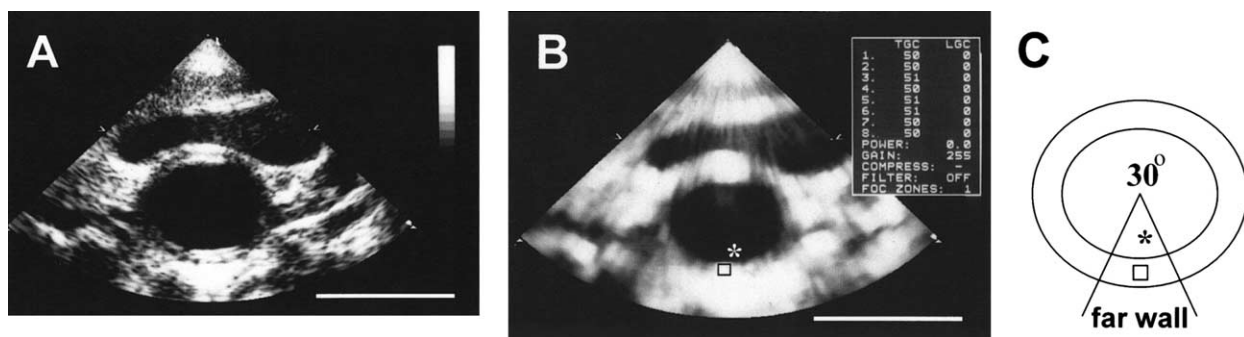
Integrated backscatter (IB) image from the carotid artery. (A) Conventional ultrasound image of common carotid artery. Intima-media thickness and diameter of artery were measured on conventional ultrasound image. Bar = 1 cm. (B and C) Integrated backscatter values in the entire far wall of the arteries (an angle span of 30° between -15° and +15°) were measured. The IB values were determined averaging the IB values from 10 sites continuously moving the region of interest above the far arterial site. Also, IB values of arterial lumen were measured just above far wall shown by an asterisk. Bar = 1 cm.
